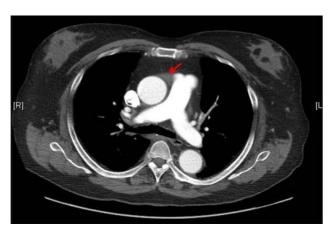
Contrast-enhanced computed tomographic nongated axial image shows the superior aortic recess of the transverse sinus (*arrow*).
